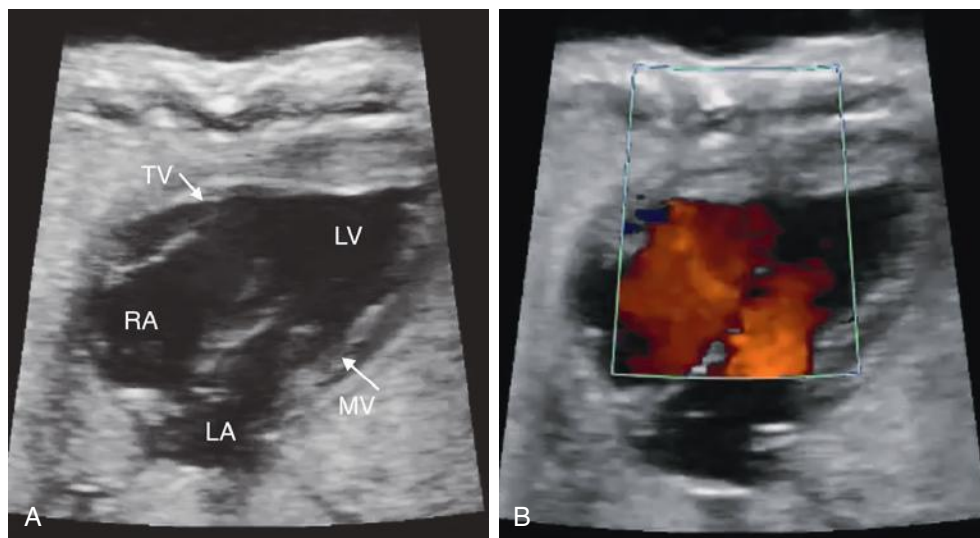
Double-inlet left ventricle (LV) by two-dimensional imaging (A) and color Doppler imaging (B). Both the tricuspid valve (TV) and the mitral valve (MV) open into the LV. The right ventricle is severely hypoplastic and not visible from this view. LA, left atrium; RA, right atrium.
